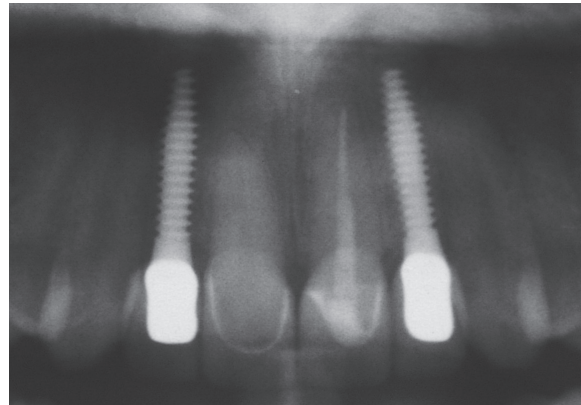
Radiograph of restorations seated
